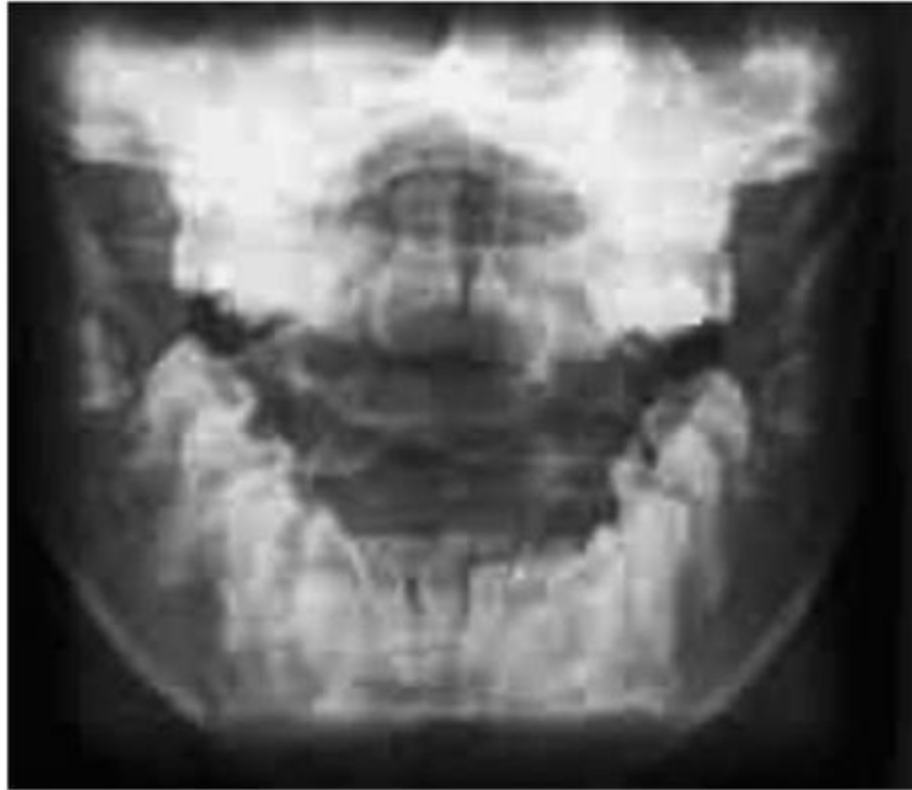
Annotated AP cervical spine radiograph.
